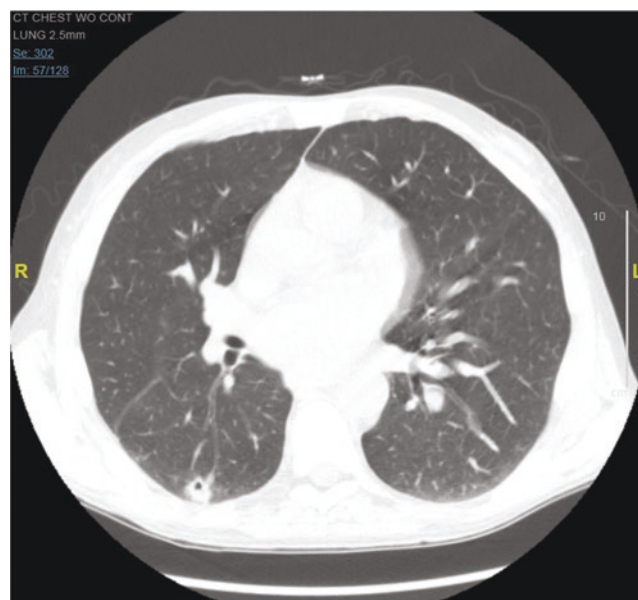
Chest CT showed a 1.5 cm peripheral nodule with cavitation in the right lower lobe with mild atelectasis in the lung bases
